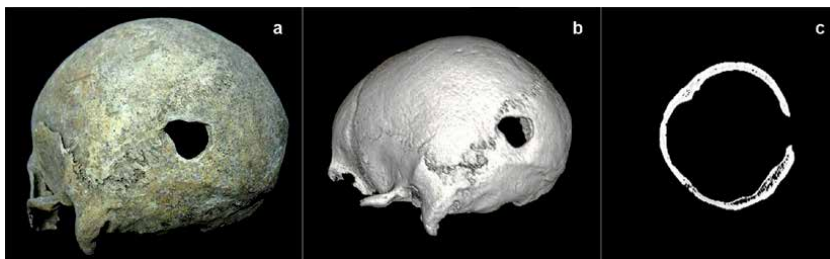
“VIE r.s. 18”: Photo report (a) and CT scan (b), occipital-lateral view; X-ray (c), coronal view.
